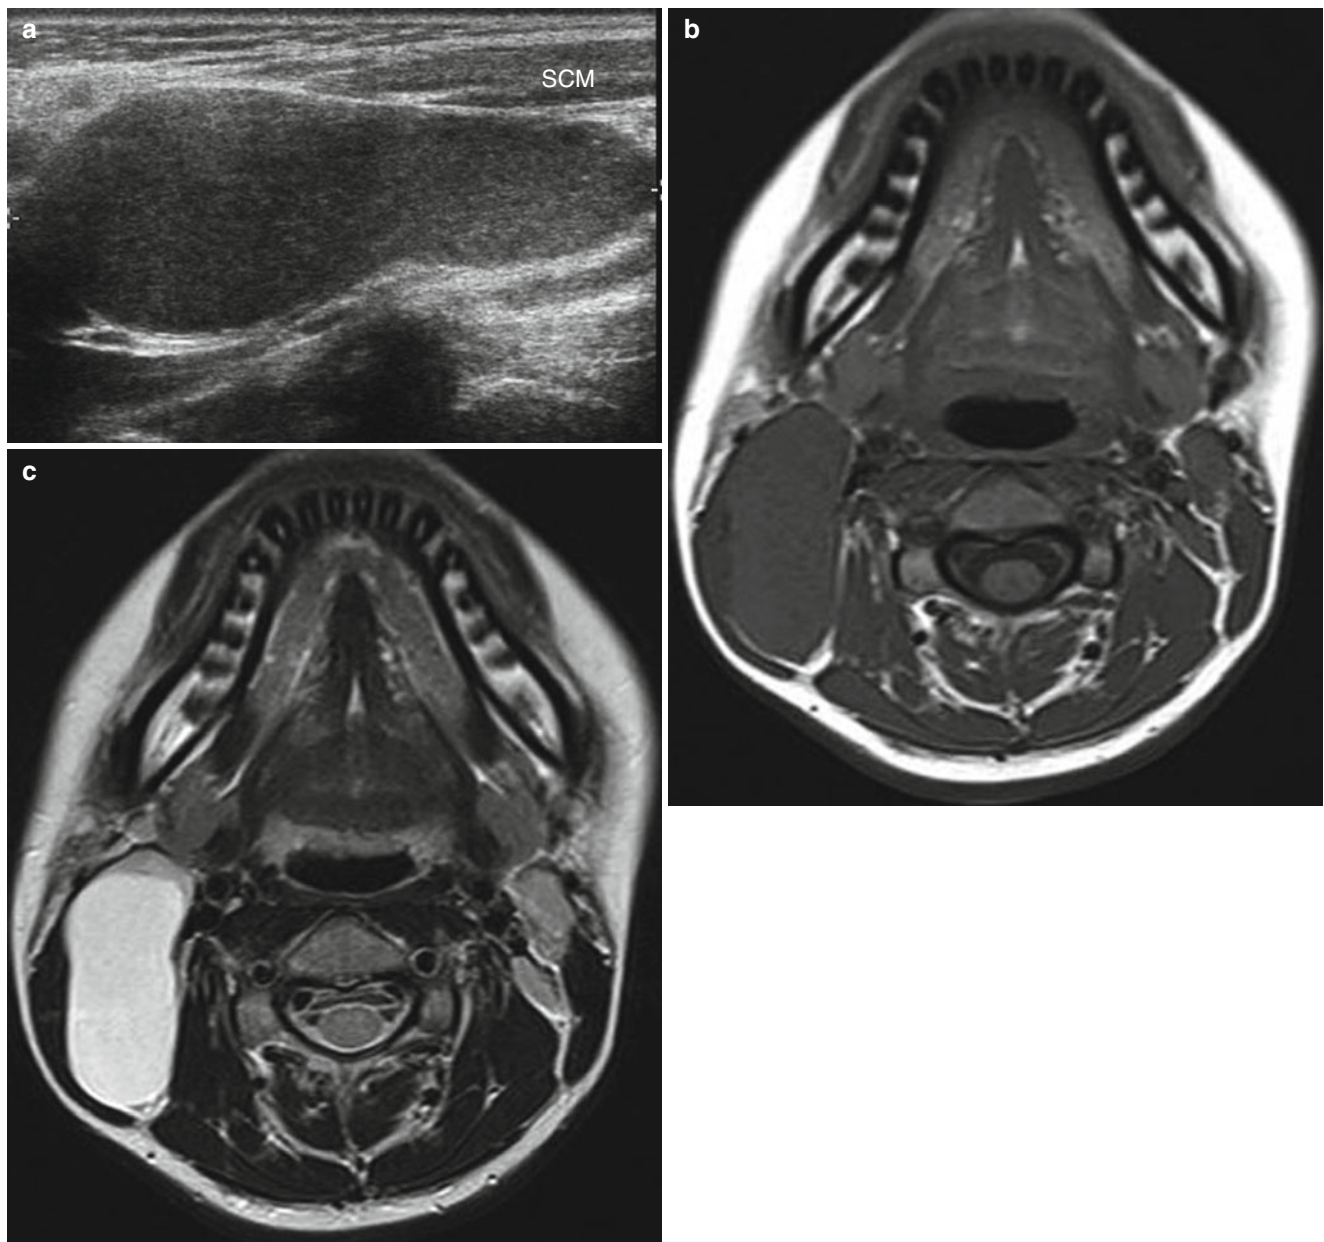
Third branchial cleft cyst in a 16-year-old girl. (a) US shows an elongated cyst along the posterior aspect of the right sternocleidomastoid (SCM) muscle. Note the internal echogenic debridements indicating complicated or proteinaceous content. (b) Axial T1-weighted
